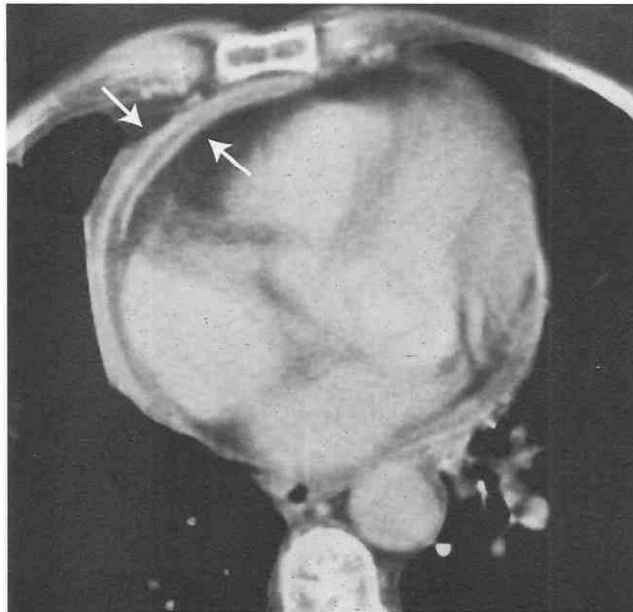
Postradiation pericardial thickening. Axial contrast-enhanced CT image shows marked thickening of the visceral and parietal pericardium (*arrows*). The patient had received radiation for lung carcinoma.
